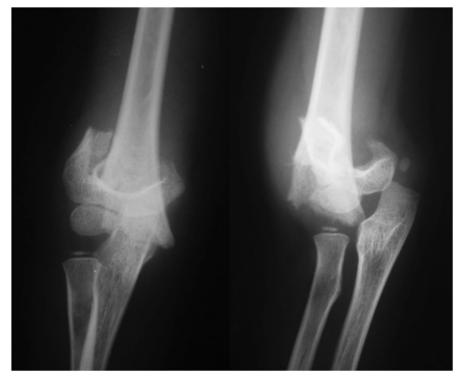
Anteroposterior and lateral view radiograph of a supracondylar fracture of the right humerus.
